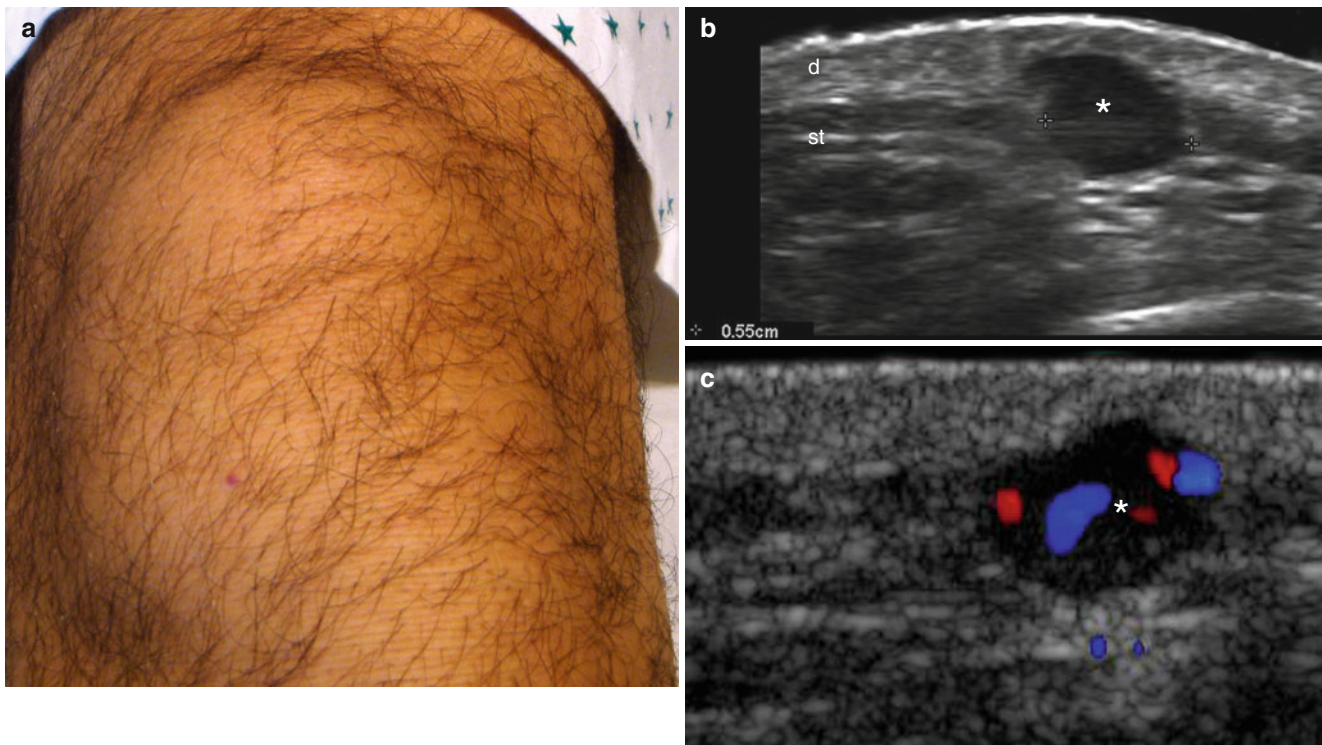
(a–c) Glomangioma. (a) Unremarkable clinical view of the anterior aspect of the knee. Nevertheless, the patient presented with tenderness in correlation with the sonographic findings. (b) Grey scale ultrasound (transverse view) demonstrates 0.55 cm well-defined
